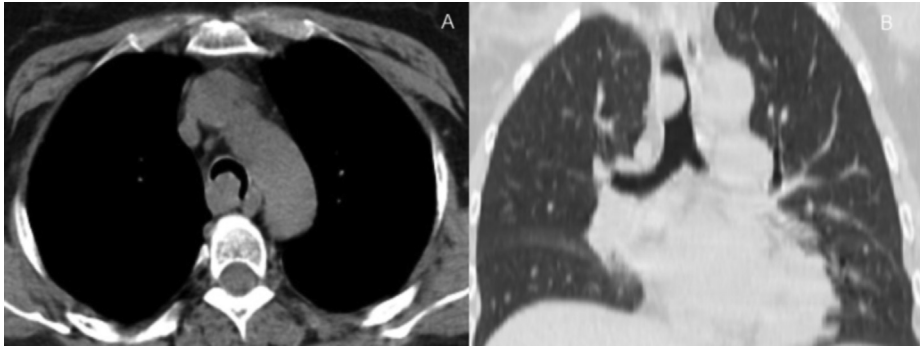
Pulmonary CT scan images reformatted in oblique axial (a) and coronal (b) planes showed a polypoid lesion with sizes of 22 × 19 mm in the trachea with a posterior soft tissue extension.
